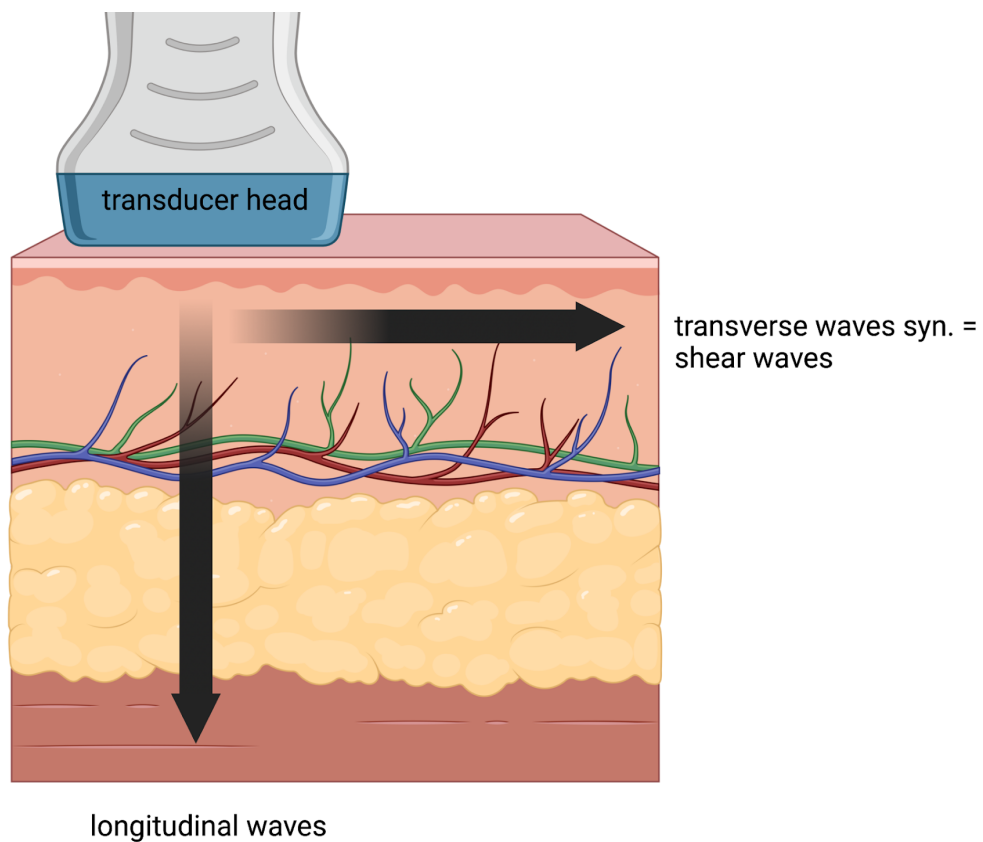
Representation of longitudinal waves and transverse/shear waves in tissue. (Own representation) The ultrasound transducer head sends longitudinal waves (left arrow) into the body tissue which results in the simultaneous emission of shear waves (right arrow) which travel through the body tissue perpendicularly from the longitudinal waves.
